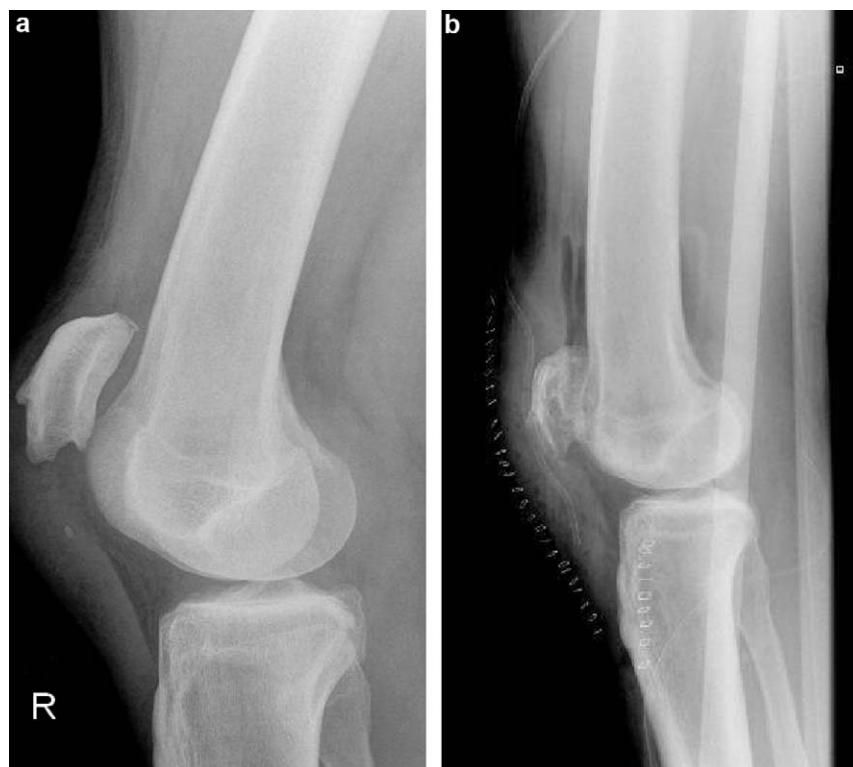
a: lateral X-ray after the initial injury shows a patella alta (Caton Deschamps index: 1.5); b: postoperative lateral view of the operated knee: patellar height is normal.
